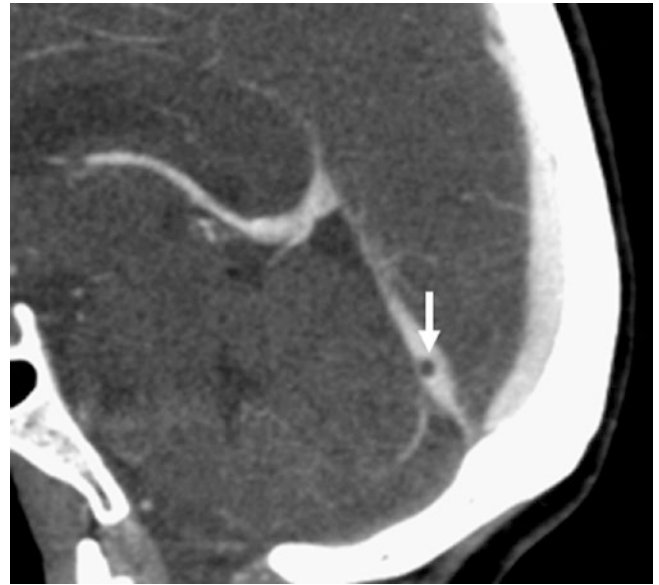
16-year-old with a filling defect (*arrows*) within the StS on axial T2WI MRI (*top left*); the defect is well-circumscribed and suppresses along with CSF on FLAIR (*top right*), indicating an arachnoid
